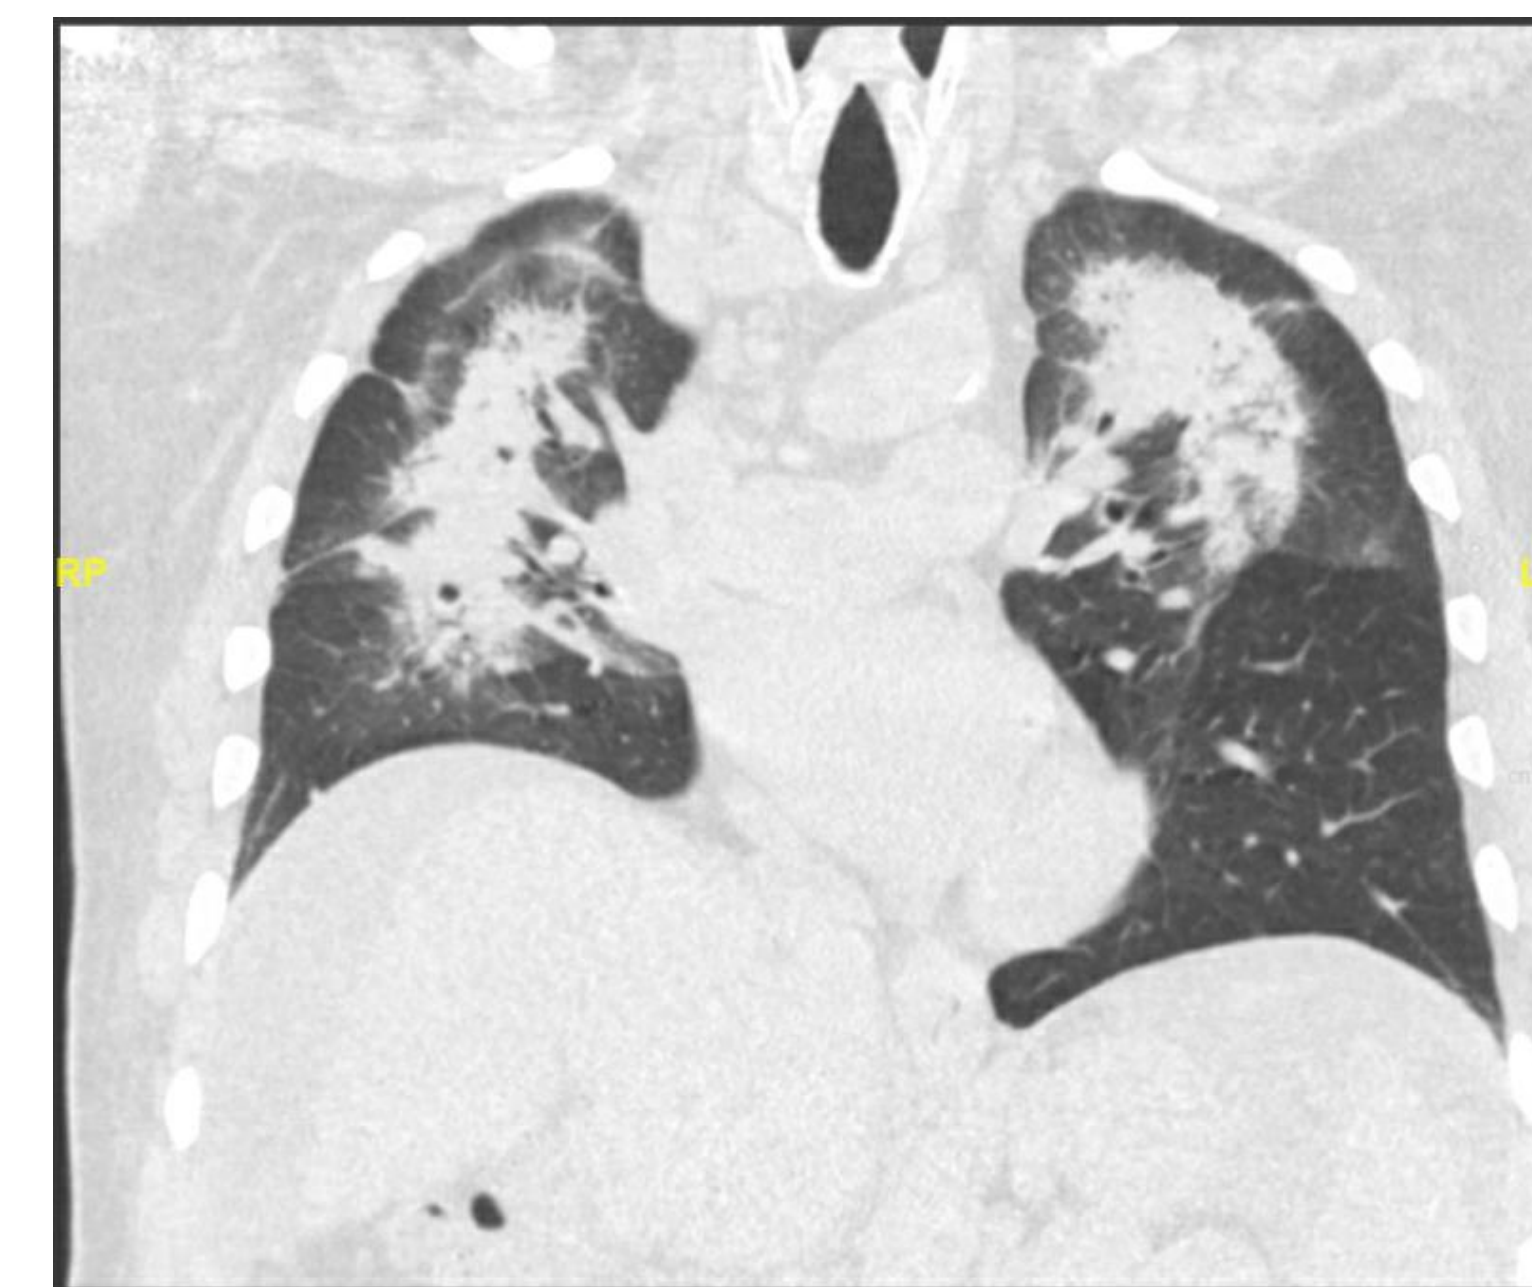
CT chest of case 1; 2 months post Y-90
